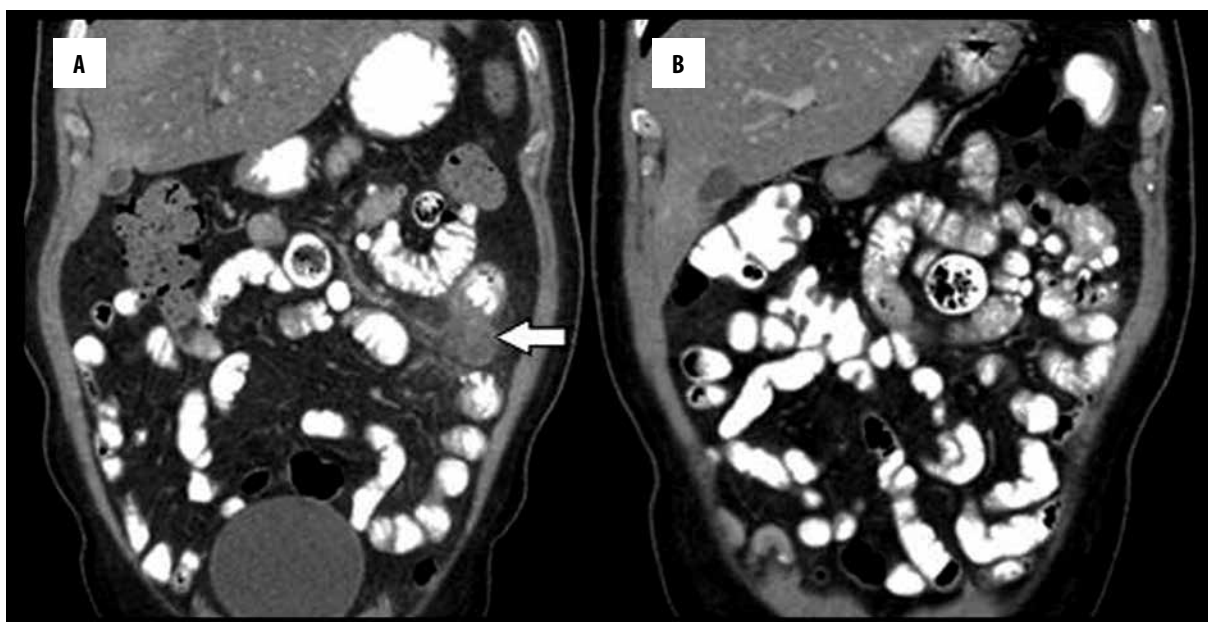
(A) Abdominal CT coronal reformatted images demonstrated the inflamed diverticulum (arrow); (B) Control CT 4 weeks after the medical therapy showed a jejunal diverticulum and no other pathological processes.
